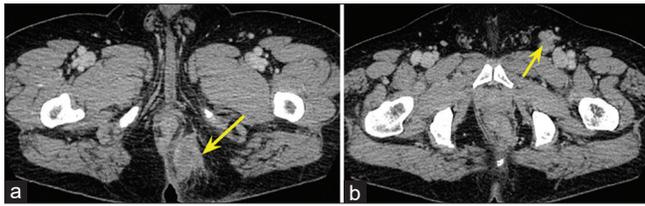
Clinical staging by abdominal computed tomography scan. (a) A heterogeneous enhancing tumor in the left posterior to the anus (yellow arrow). (b) Enlarged lymph nodes in the left inguinal area (yellow arrow)
